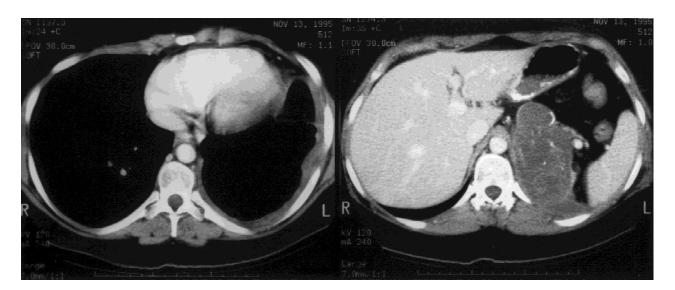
CT scan of the chest (left) and abdomen (right) 2 weeks after cycle 9 of paclitaxel. The patient had also received six cycles of platinum and paclitaxel. The tumor size was reduced to 9×6 cm, with persistent left pleural thickening.
